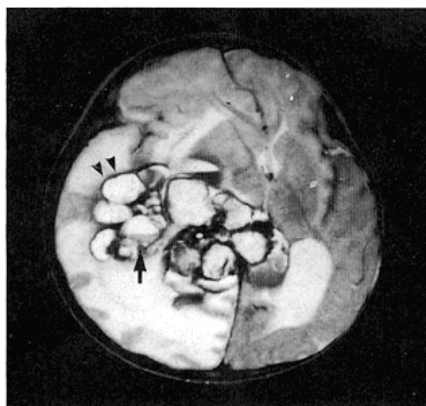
T2-weighted magnetic resonance image (axial view). No signal rim surrounded multiple hyperintense areas (*arrowheads*) in this T2-weighted image. Nodule was also noted inside (*arrow*).
